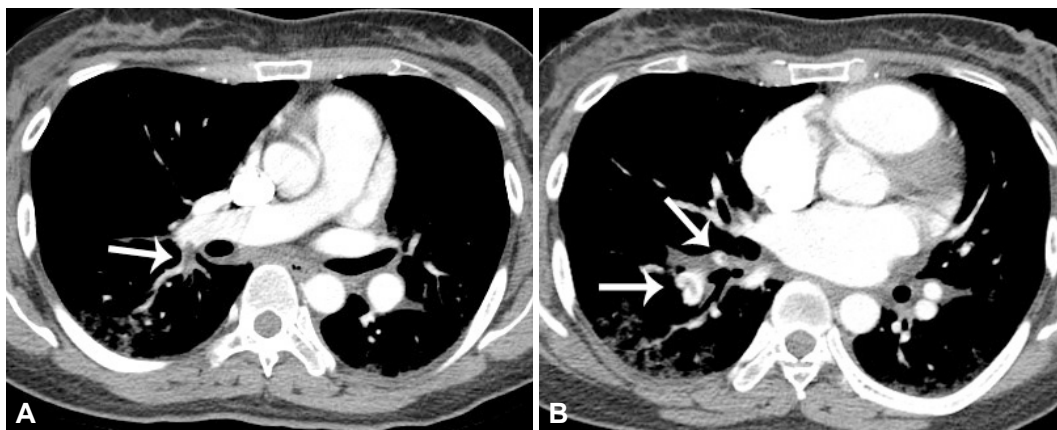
Computed tomography in a 38-year-old woman with pulmonary embolism. A: this shows an intraluminal filling defect in the right lower lobe pulmonary artery (arrow). B: the clot is also visible in anterior and posterior basal segment arteries (arrows).
